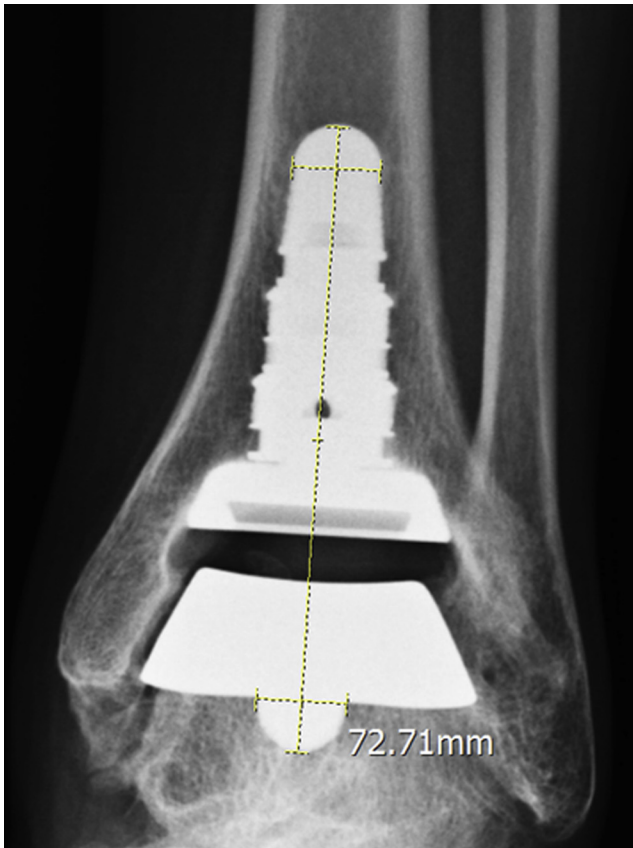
Implant migration measurements for the stemmed component. Using anteroposterior radiographs, measurements were taken from the apex of the tibial component to the most distal aspect of the talar stem.
